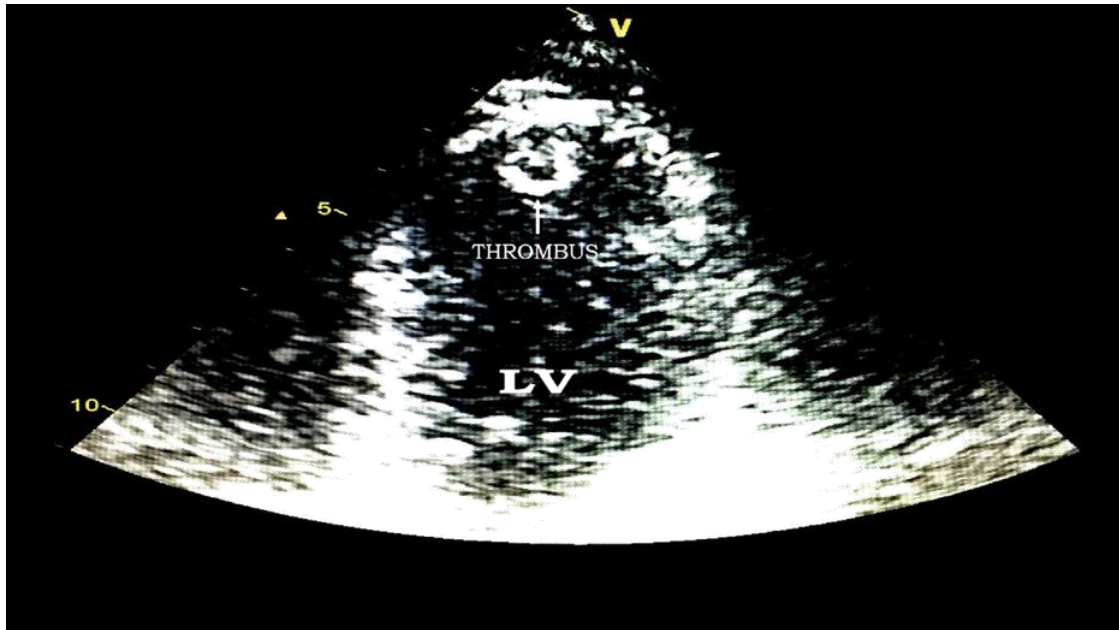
Echocardiographic 4 chamber view of the left ventricle during the initial presentation. Note the presence of the pedunculated LV apical thrombus protruding into the LV cavity.
